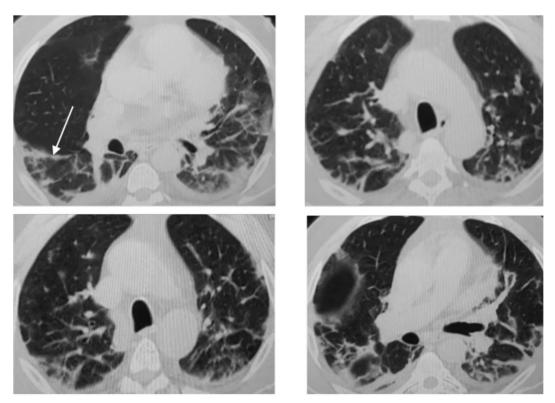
50 male patient complainting of fever and dyspnea, Axial CT chest parenchymal window, Bilateral peripherally located reticular shadows.
